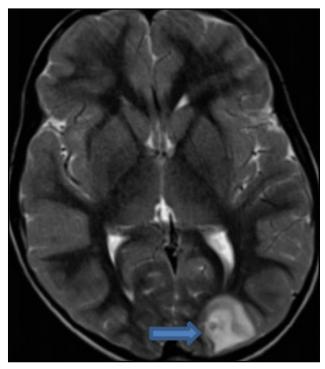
CT Head showing lesion in Left occipital region which peripheral enhancement on contrast with perilesional edema s/o Solitary NCC lesion
